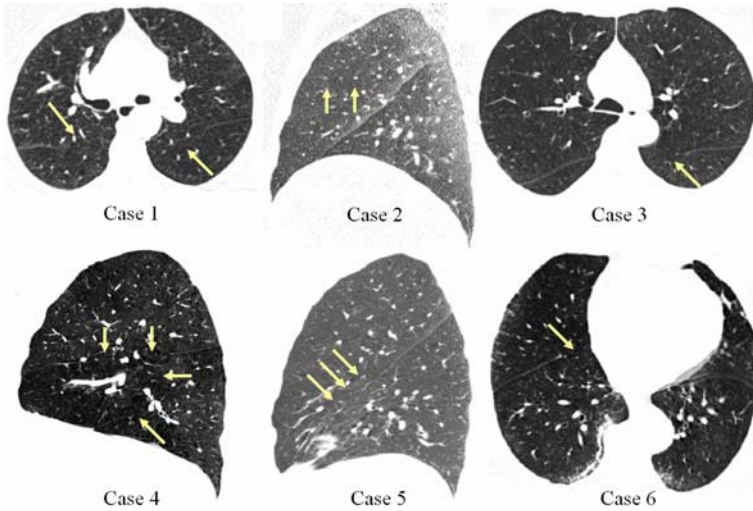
CT slices of the datasets used in this study. Arrows indicate partial fissures. Case 1: low dose, expiratory scan, severe emphysema; Case 2: low dose, expiratory scan, high BMI, right horizontal fissure nearly absent (feature directly below arrows *appears* as fissure in this slice); Case 3: low dose, expiratory scan, moderate emphysema; Case 4: inspiratory scan, moderate emphysema; Case 5: low dose, expiratory scan, marked fissure aberration; Case 6: inspiratory scan, high BMI, mild diffuse interstitial abnormalities.
